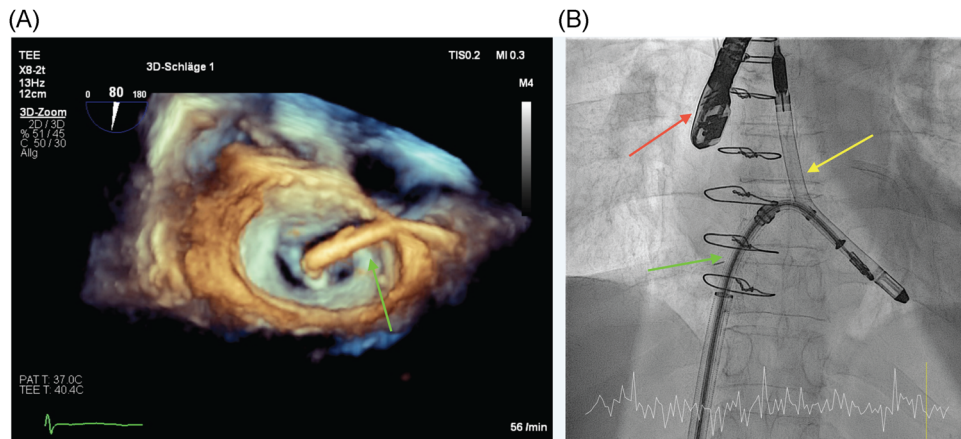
MitraClip implantation procedure. (A) Intraoperative transesophageal echocardiography (TEE) three-dimensional reconstruction visualization showing the MitraClip delivery catheter (green arrow) inserted through the atrioseptostomy. (B) Concordant fluoroscopic imaging with the Impella 5.5 device (yellow arrow) and the tip of the echocardiographic probe (red arrow). Wire cerclages after previous sternotomy closure can be seen in the middle of the picture
